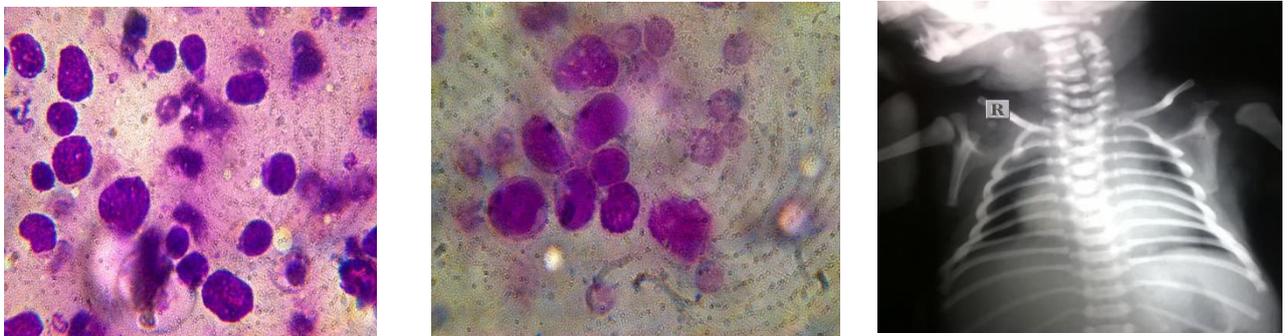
& 5 Bone Marrow smear showing myeloblasts and monoblasts and Fig 6 X-Ray chest showing cardiomegaly.
